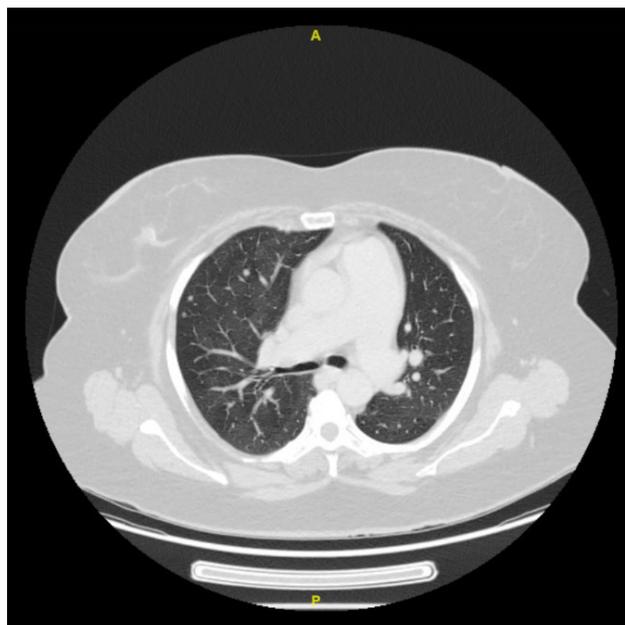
CT thorax showing multiple bilateral variably sized pulmonary nodules, initially thought to be secondary deposits.
